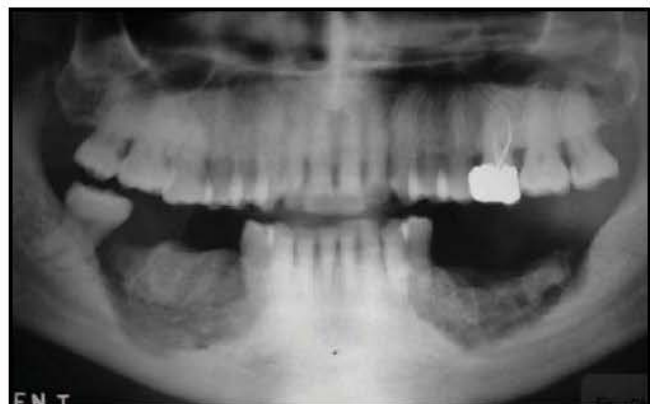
Radiograph showing the status of the affected bone in December 2005.
